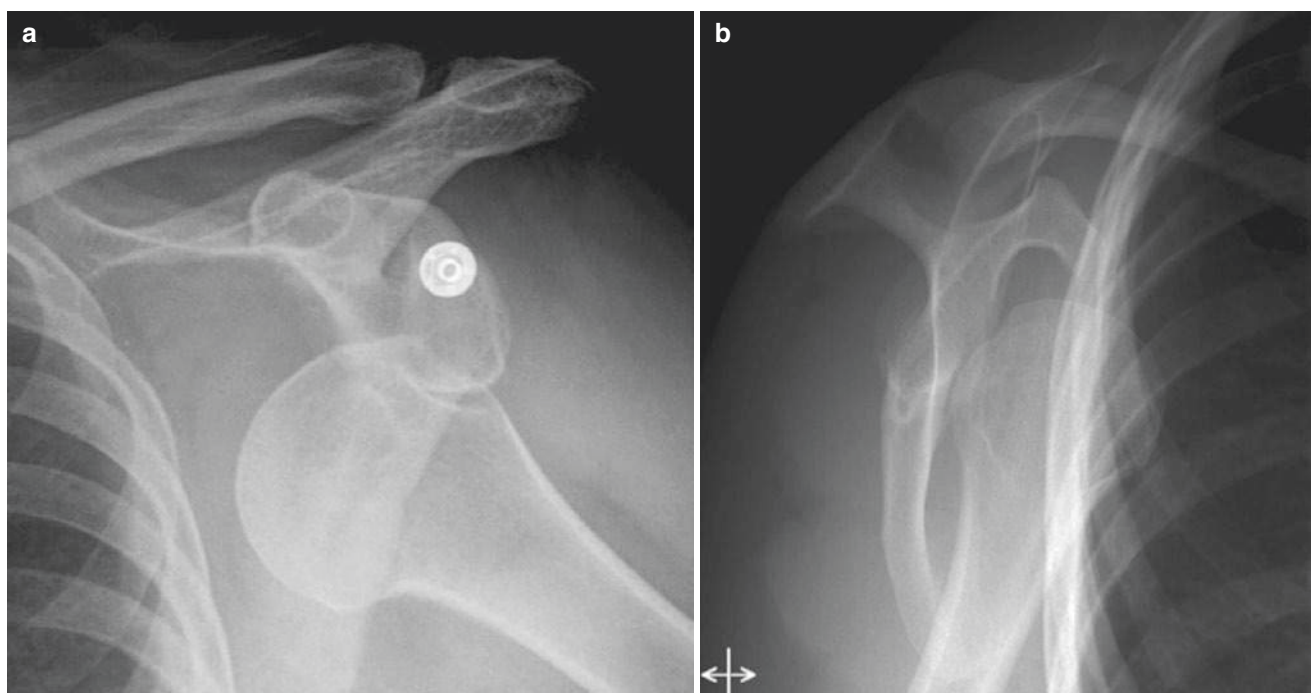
Anterior shoulder dislocation. AP (a) and scapular Y-view (b) radiographs demonstrate anteroinferior glenohumeral dislocation
